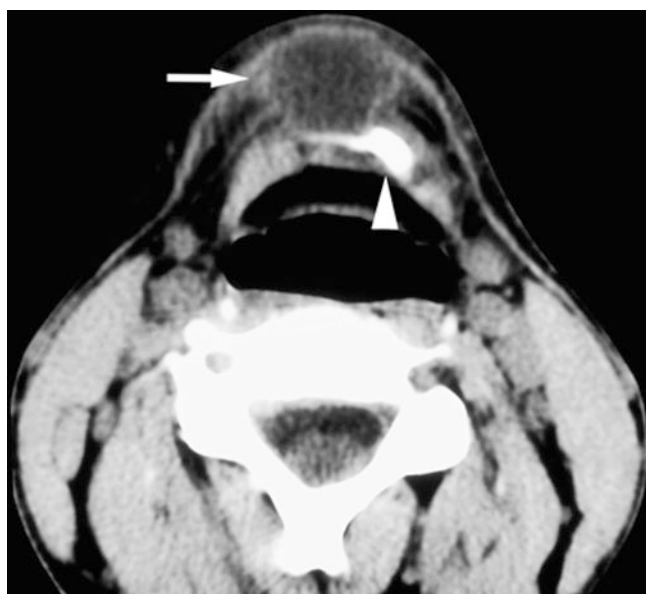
Thyroglossal duct cyst; 29-year-old male with lump in the midline of the neck, anterior to the hyoid bone. Axial post-contrast CT image shows well-defined hypodense area with enhancing peripheral rim in the midline (*arrow*) anterior to the hyoid bone (*arrowhead*)
